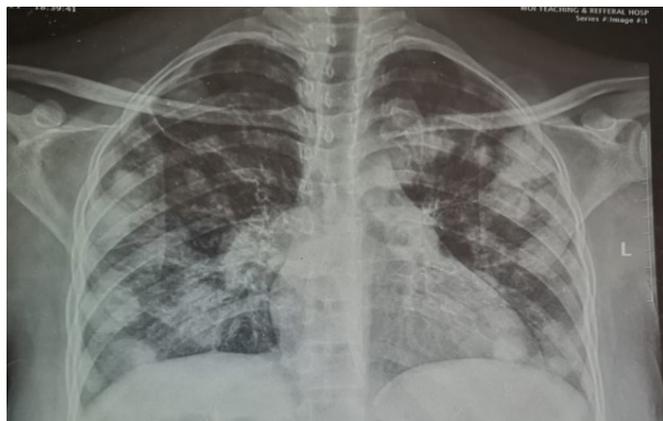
Chest X-ray findings showing multiple diffuse dense bilateral pulmonary nodules highly suggestive of metastatic gestational trophoblastic neoplasia.
